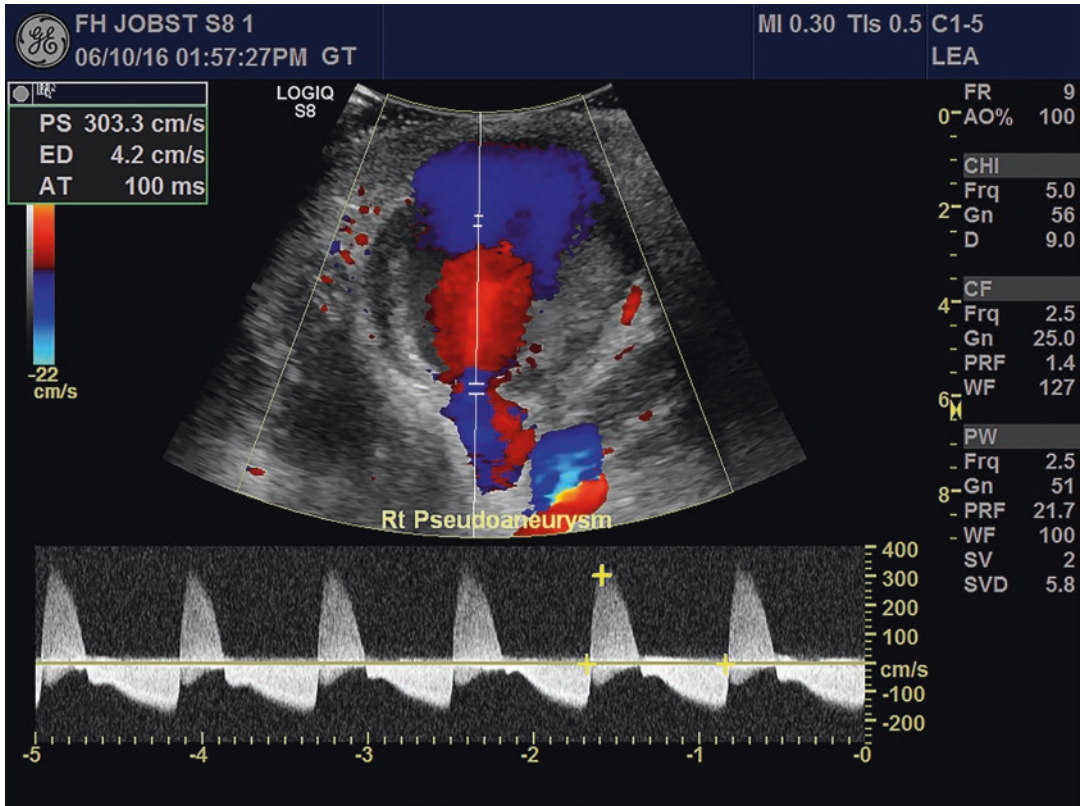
Ultrasound findings demonstrating “to-fro” flow leading from an artery to a blind-ended cavity typical for pseudoaneurysms
